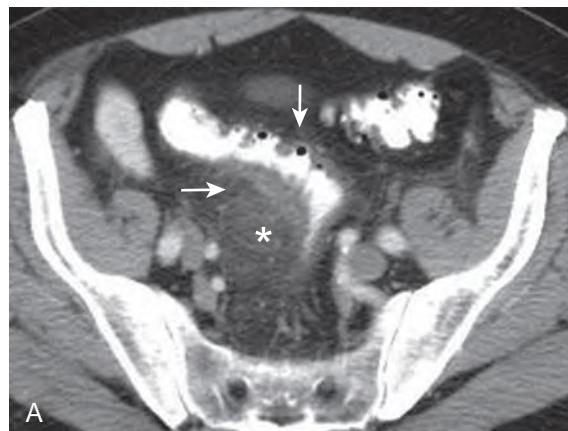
Pseudomembranous colitis in a man who presented with diarrhea and fever. CT image demonstrates marked circumferential colon wall thickening (open arrows) in patient with pseudomembranous colitis.
